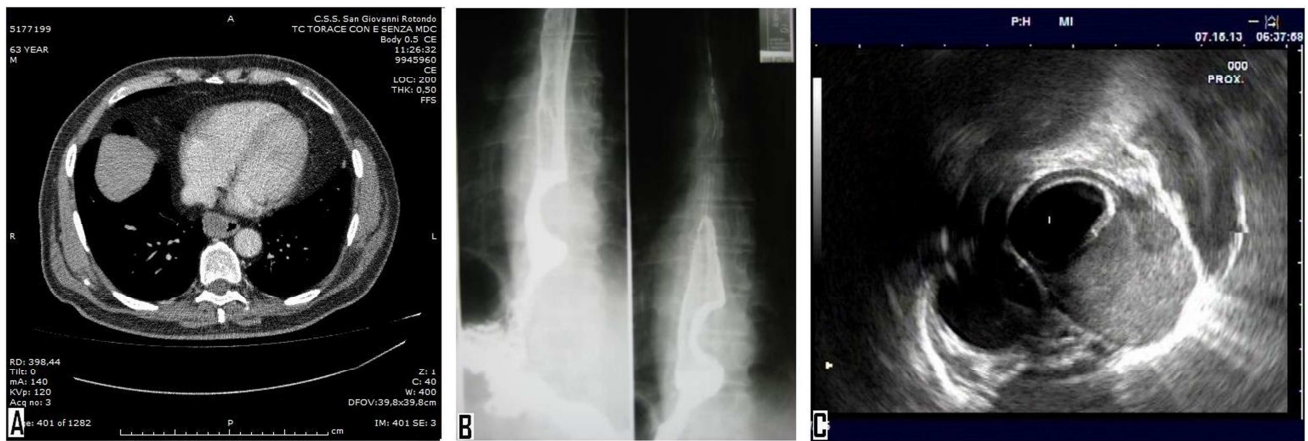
Preoperative imaging evaluation of E-GIST: A. Transversal sections of chest computed tomography. B. Esophageal radiography (barium meal). C. Echoendoscopy.
